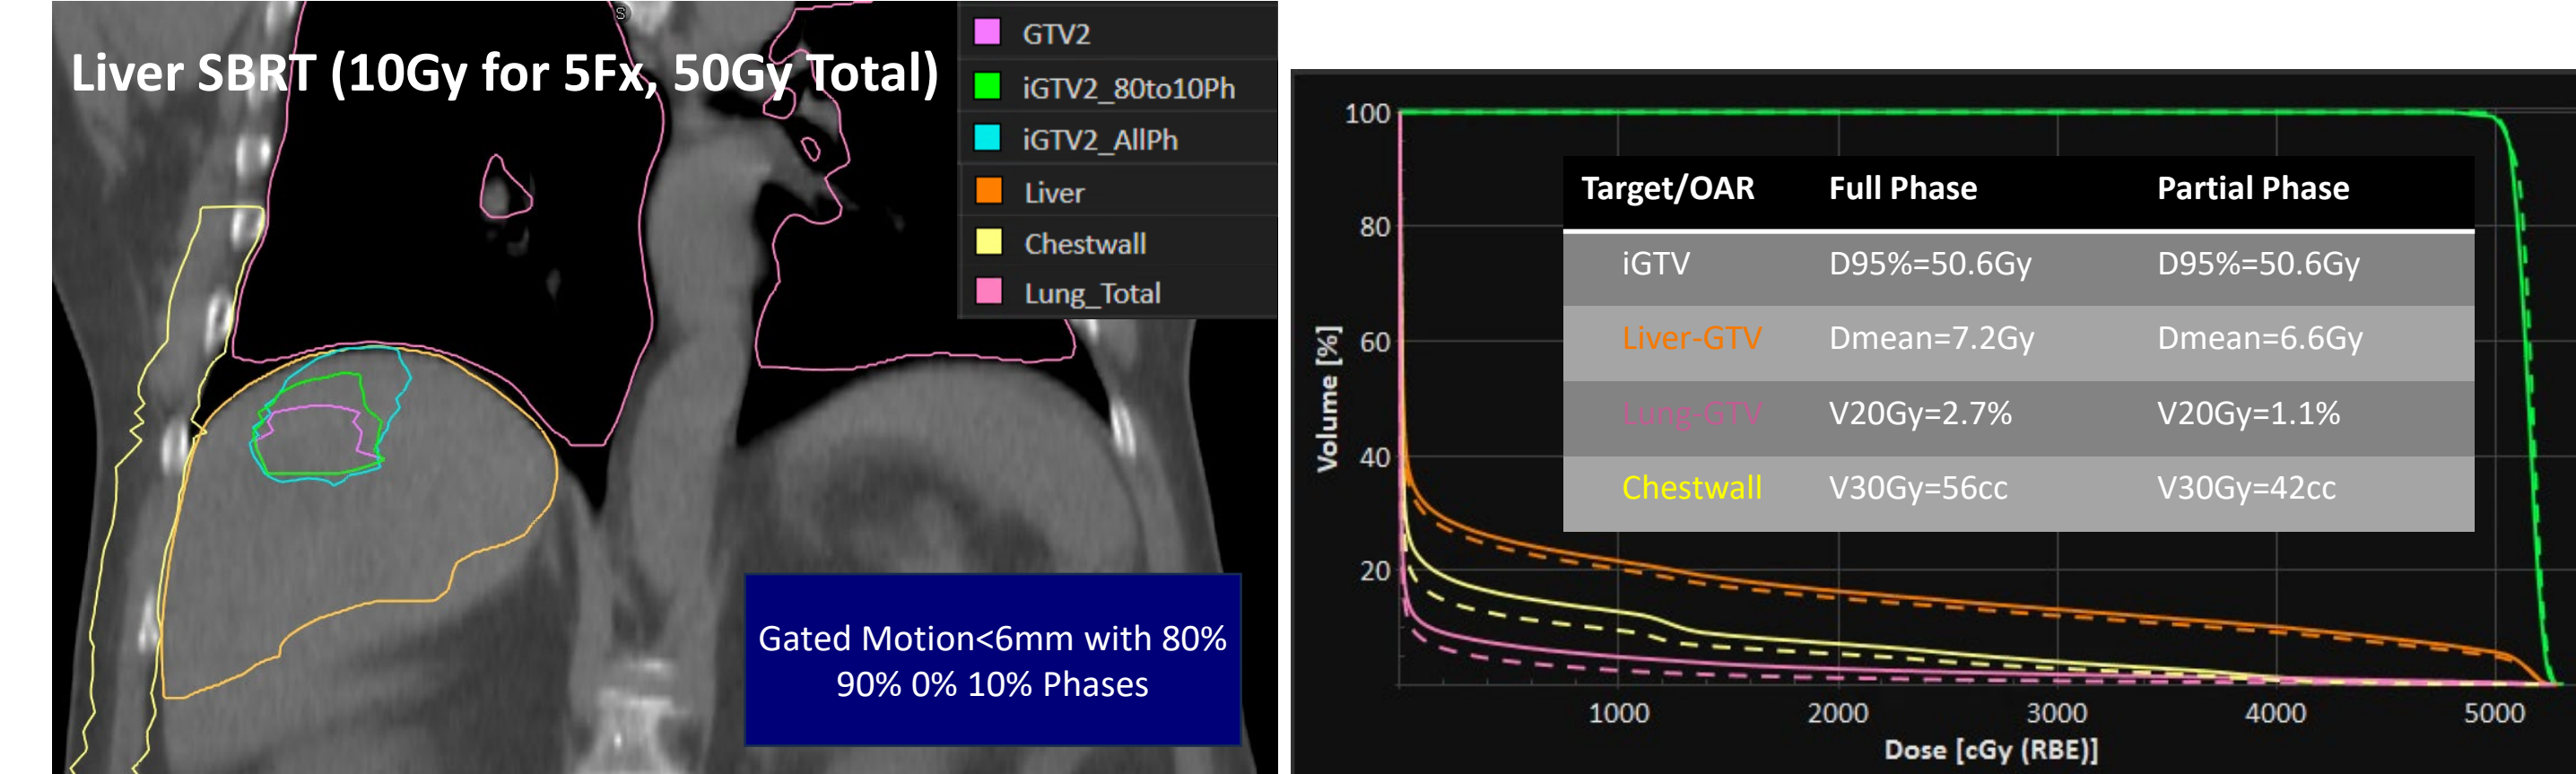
Example treatment plans for full-phase and partial-phase (80-10%) CT scans, including dose distribution, dose-volume histogram, and volume changes in the target and lung. 80-10% phase was chosen for the gated plan to reduce motion from 12mm to < 6mm. Equivalent beam angles were used for the two plans. Note: iGTV=GTV+internal intrafraction target motion
